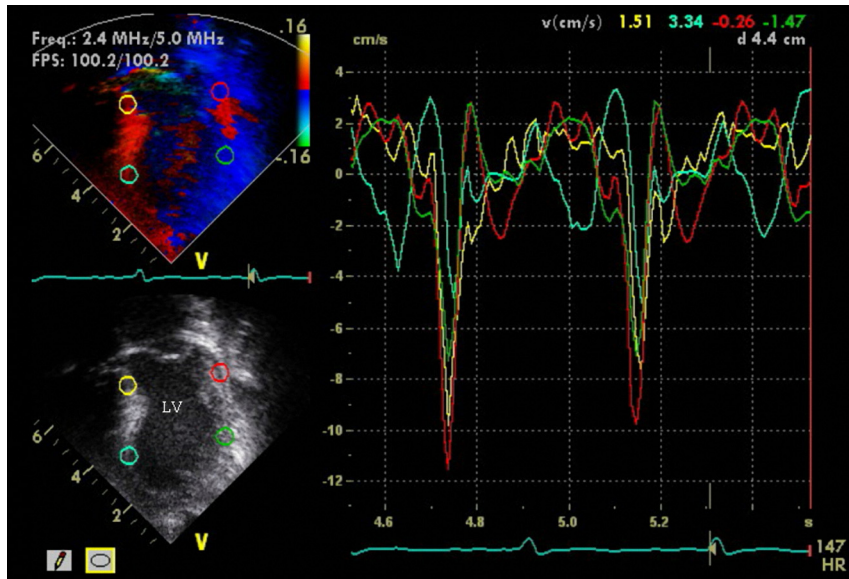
Tissue Doppler Imaging showing apical wall motion to be both significantly dyskinetic and hypokinetic with respect to the mid and basal segment of the left ventricle.
